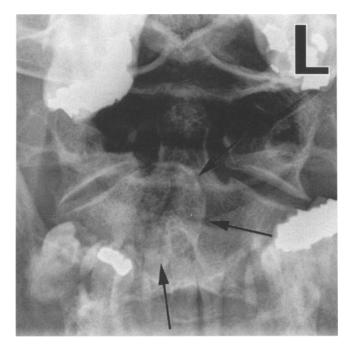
Postero-anterior radiograph of the dens demonstrating an oval mass (black arrows) between C1 and C2 at the right side
